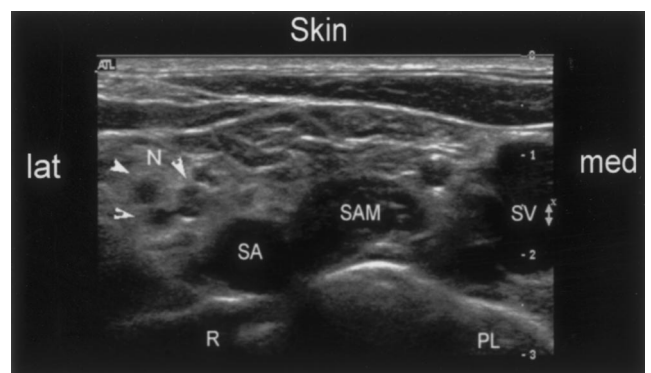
Transverse sonogram in the supraclavicular region shows brachial plexus as a group of hypoechoic nodules (N with arrows) lateral to subclavian artery (SA) and cephalad to the first rib (R). PL = pleura; SAM = scalenus anterior muscle; SV = subclavian vein.
